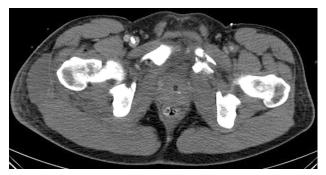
Pelvis CT. There is marked edema and hematoma adjacent to the right hip. Note fracture of left pelvic ramus.
